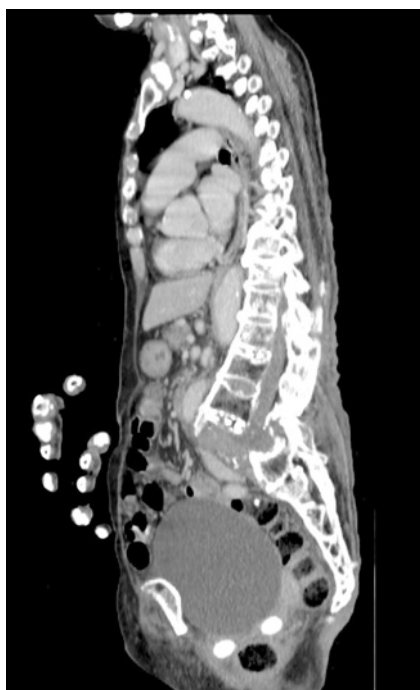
Ten days after the injury, contrast-enhanced CT, sagittal.
